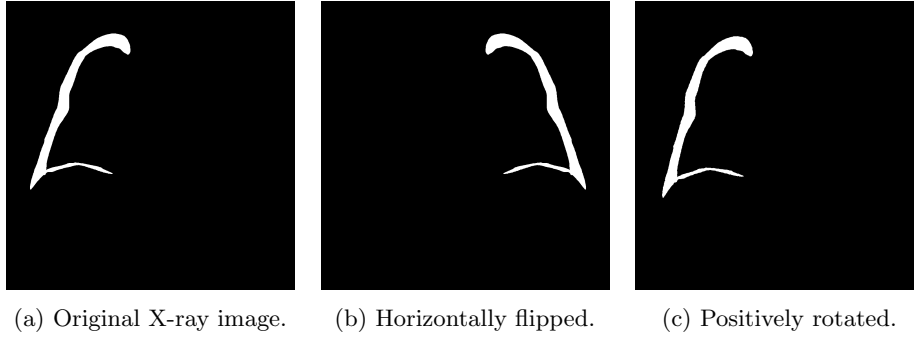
Sample chest X-ray mask along with the applied augmentation.
